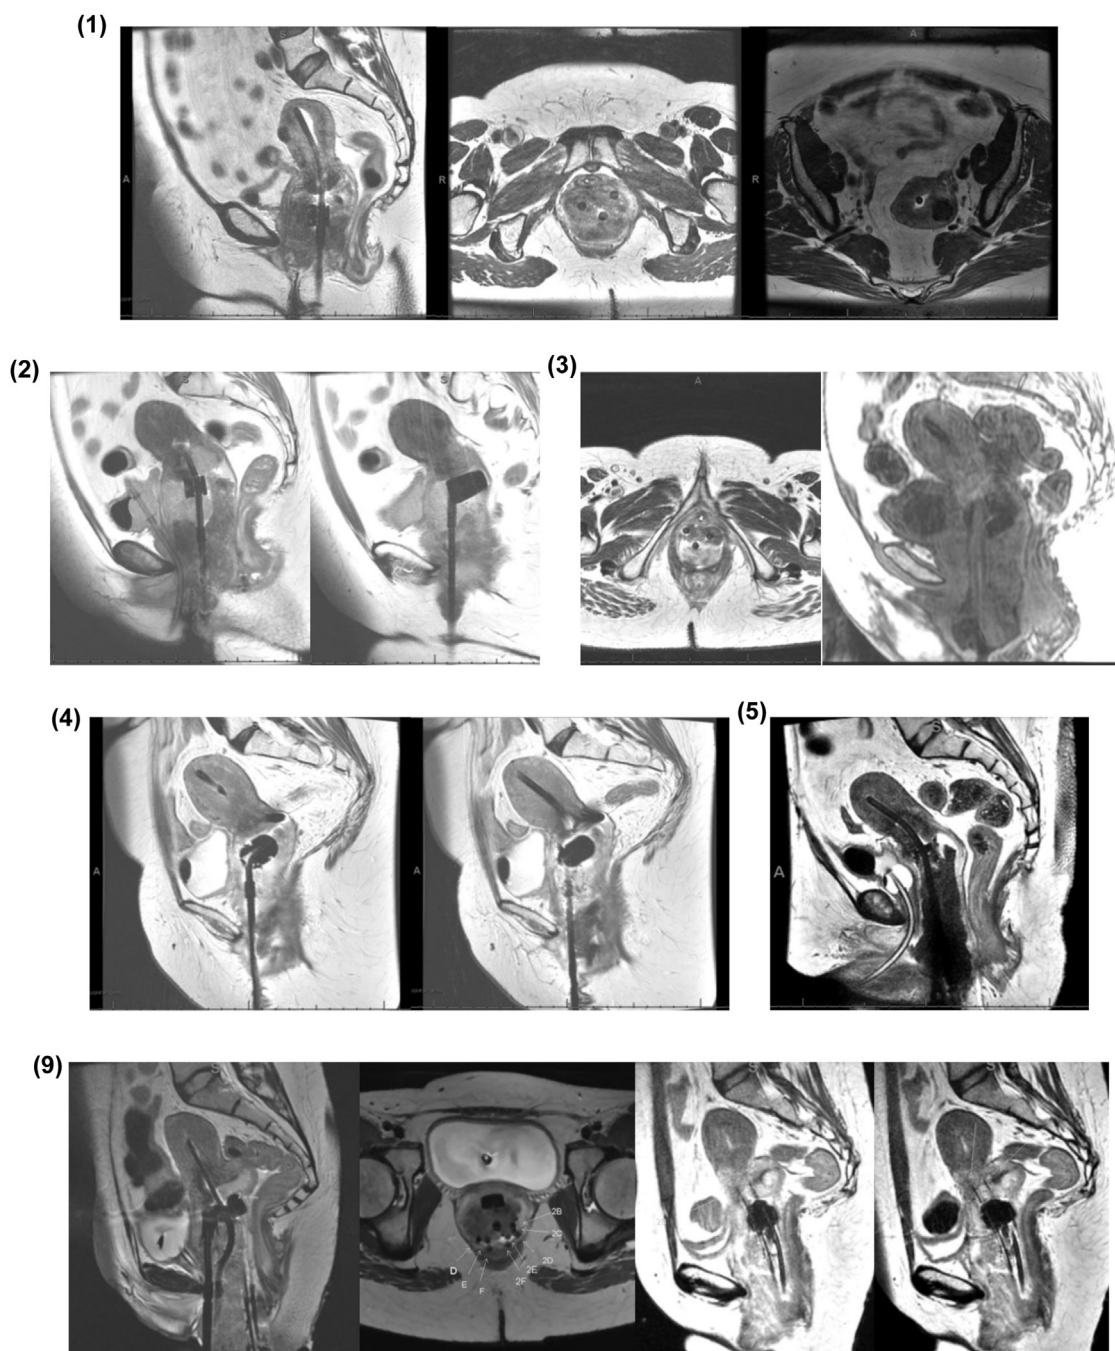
Example T2-weighted MRI images demonstrating visibility of the C4:S line markers within the gynecologic brachytherapy applicator tandem-and-ovoids: on 1.5-T (cases 1–3) and 3.0-T (cases 4–5, 9 [interstitial]). Labeled by case number. White arrows label interstitial catheter positions for case 9.
